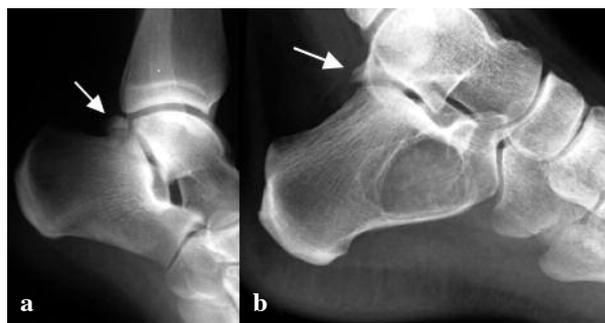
Lateral radiographs in posterior Impingement - (a) 'Os trigonum' located at the posterior aspect of the tibiotalar joint (b) 'Stieda process' projecting from the talus.
